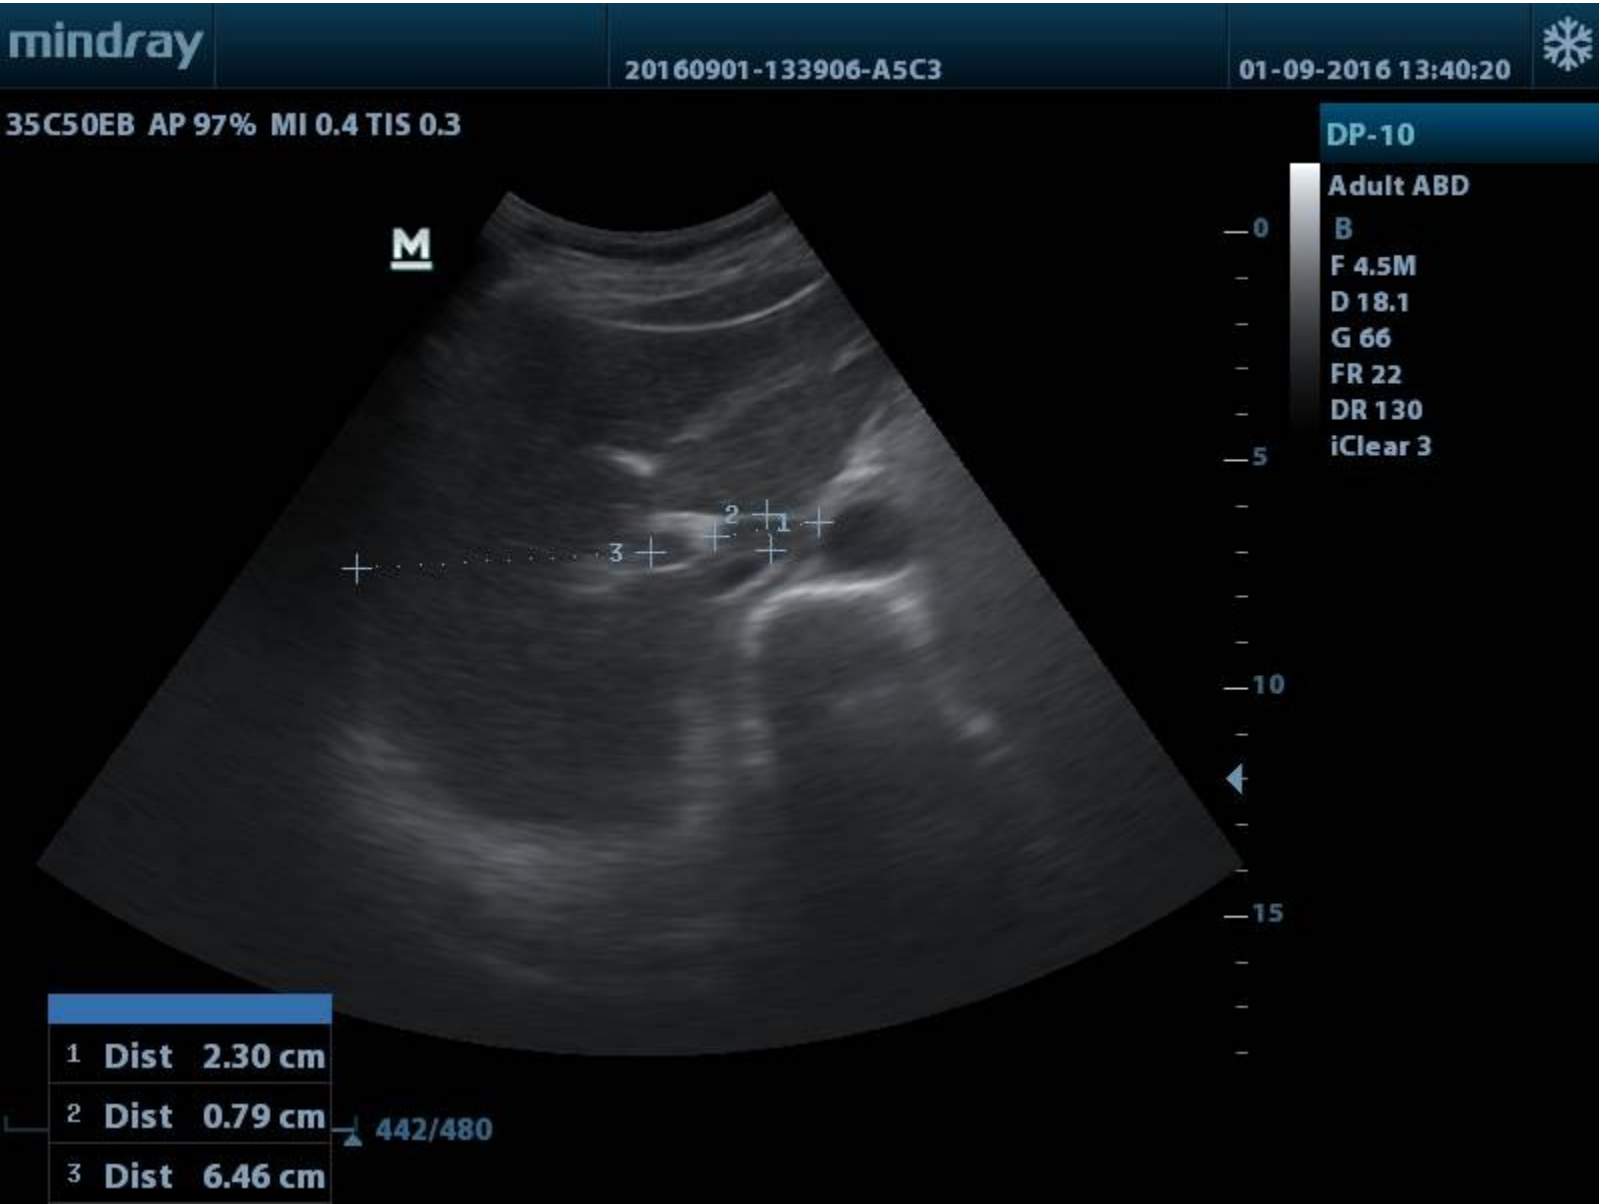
transverse ultrasound image for male (29 years) shows measurements of caudate lobe right to left, Anteroposterior and right lobe diameters.
